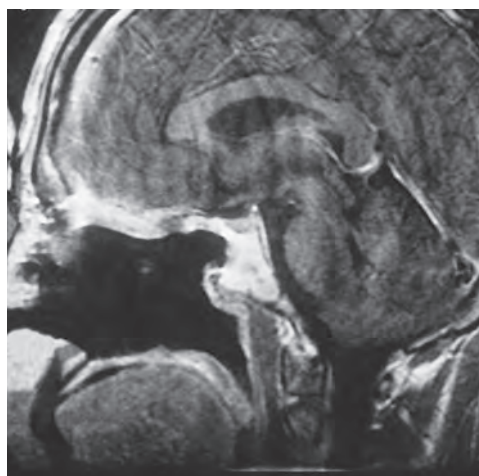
A sagittal view of the magnetic resonance imaging scan shows the tumor extending up to the cribriform plate.
